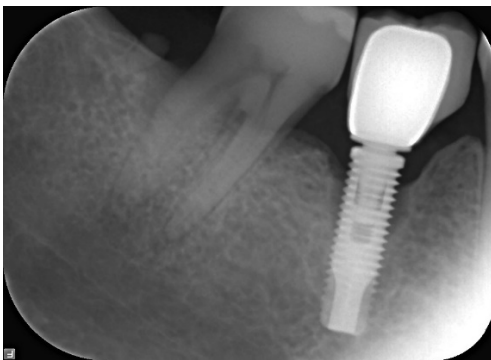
Periapical radiographic image of the region of the implant of tooth #46 showing crater-shape bone defect
